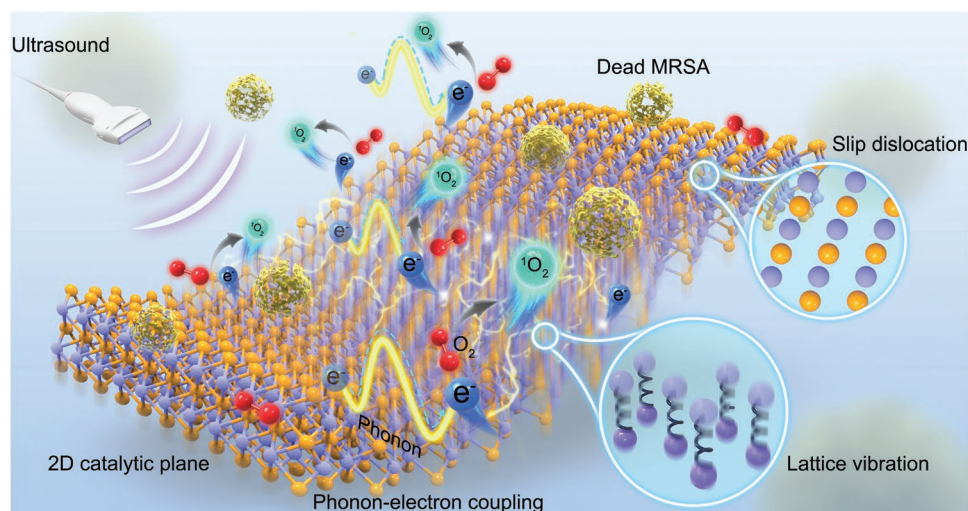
Mechanism and antibacterial performance of 2D catalytic planar defects-mediated SDT. Slip dislocation, as the catalytic site, emits large numbers of phonons through ultrasound-induced violent lattice vibrations. The phonons then drag the electrons and promote electron transfer through the phonon–electron coupling effect, significantly lowering the energy barrier for the REDOX reaction between electrons and oxygen and boosting singlet oxygen (¹O₂) generation for highly efficient MRSA eradication.
